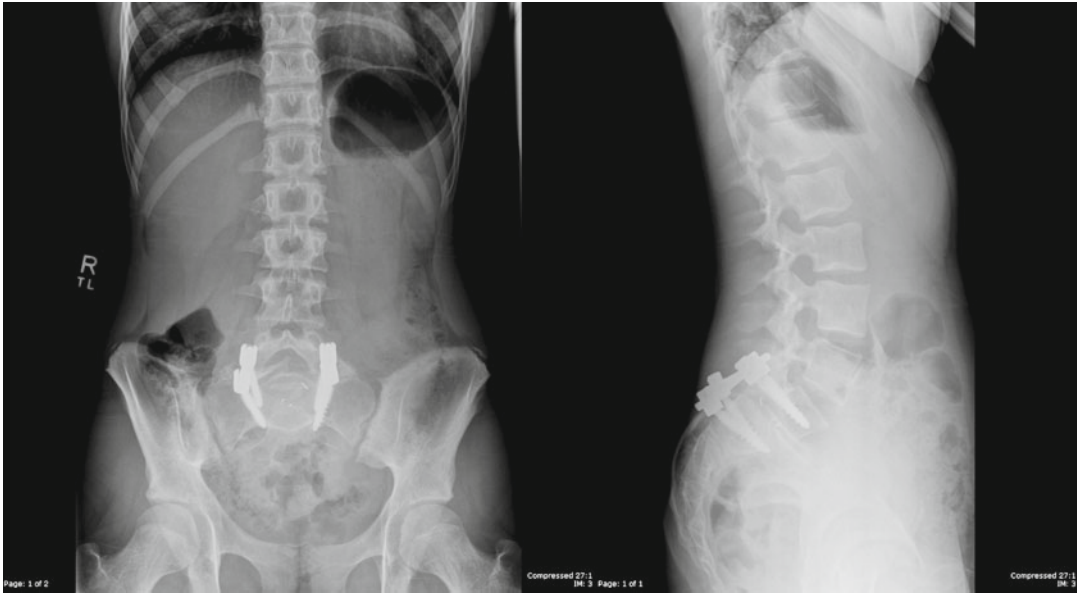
AP and lateral lumbar spine radiographs demonstrating postsurgical changes of L5–S1 posterior fusion with TLIF at L5–S1. Radiographic markers identify cage in the L5–S1 interspace
